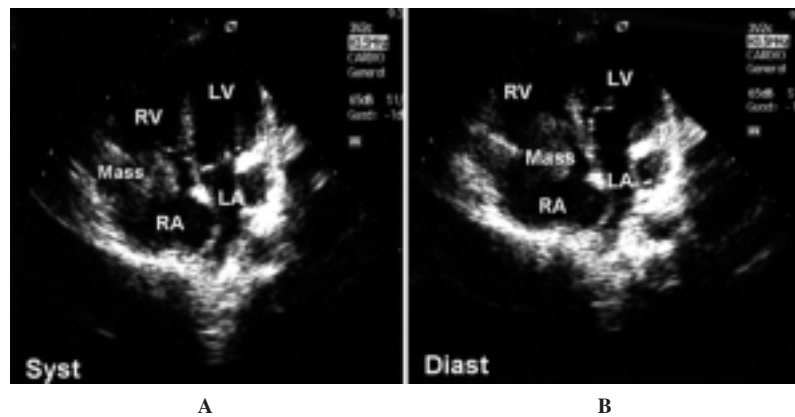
Transesophageal echocardiogram showing a thick mass, occupying most of the right atrium (RA) (A) and prolapsing into the right ventricle (RV) during diastole (B). LA = left atrium; LV = left ventricle.
